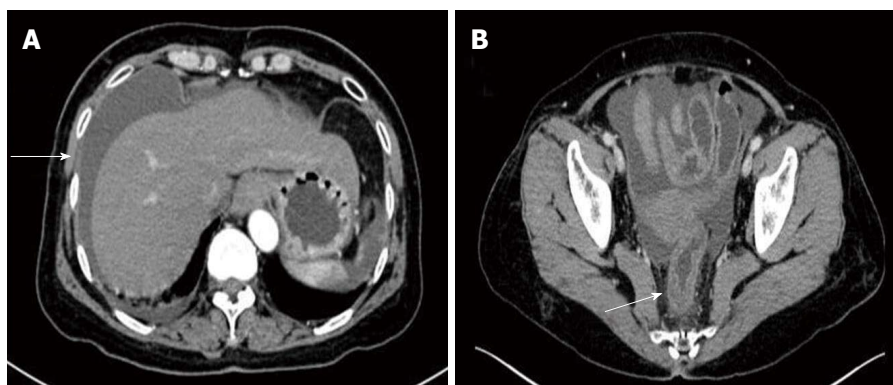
Radiological images of the abdomen. A: Computed tomography (CT) of the abdomen shows massive ascites (arrow); B: Abdominal CT shows accompanied local mild thickening of the right rear rectum wall (arrow).
